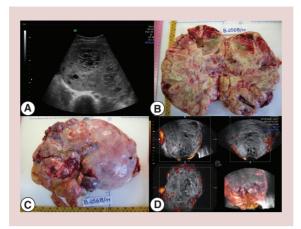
Yolk sac tumor. (A) B-mode internal macroscopy; (B & C) external surface, and (D) 3D color Doppler D of a yolk sac tumor.
